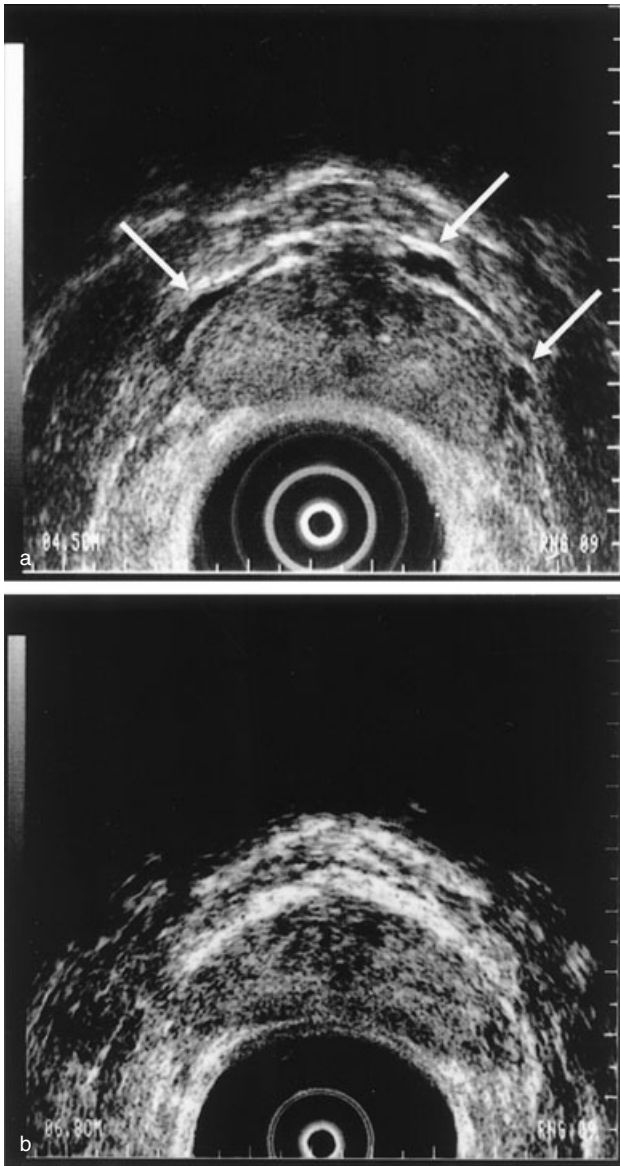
Changes in the findings of intrapelvic venous congestion using transrectal ultrasonography before and after acupuncture. Transrectal sonograms of the prostate show the changes in a patient before (a) and after acupuncture (b). The arrows show the dilation of the sonolucent zone. The maximum width of the sonolucent zone is 4.5 mm before and 1.3 mm after acupuncture.
